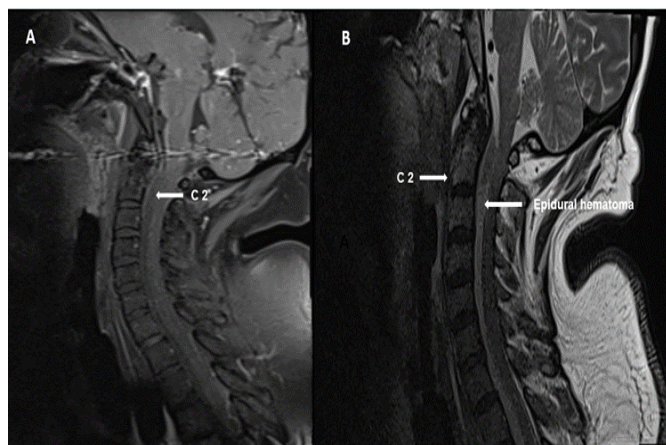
Contrast-enhanced cervicothoracic magnetic resonance imaging demonstrating an epidural hematoma extending from the C1-2 level to the upper thoracic spine, causing anterior compression of the spinal cord.
